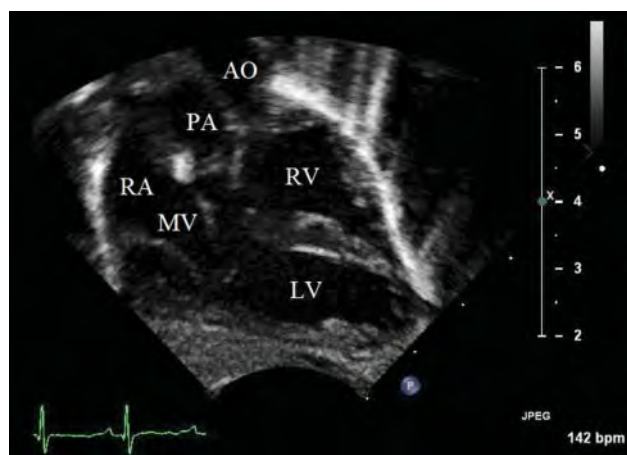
A 2D echocardiography subcostal coronal view. Pertinent visible anatomy includes mitral–pulmonic fibrous continuity (no subpulmonary conus), the smooth-walled right-sided morphologic LV, and the parallel relationship of the great vessels with the aorta leftward of the proximal pulmonary artery. AO, aorta; LV, left ventricle; MV, mitral valve; PA, pulmonary artery; RA, right atrium; RV, right ventricle.
